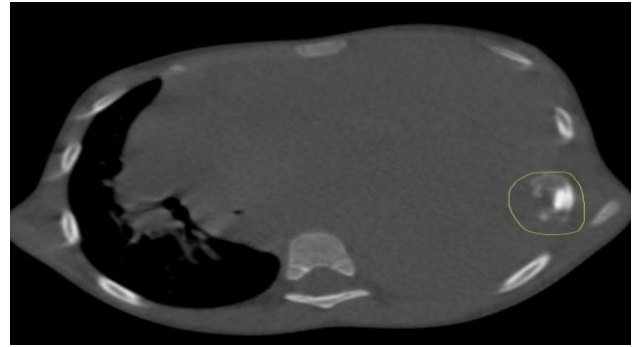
Chest CT (axial bone window) showing a soft-tissue mass arising from the left sixth rib (yellow circle) causing compressive collapse of the left lung.
